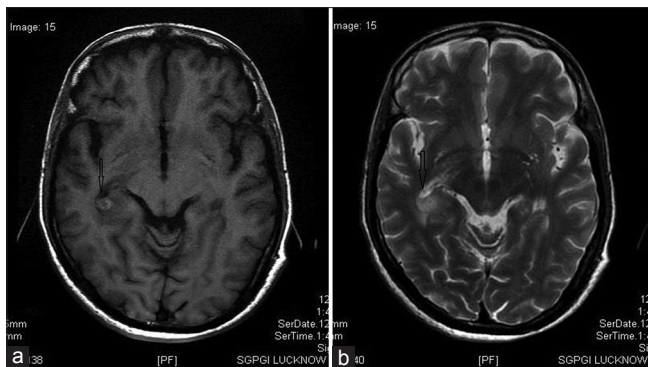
(a) Axial T1-weighted image showing rounded hyperintense lesion in the atrium of right lateral ventricle (arrow) with the surrounding white matter hypointensity suggestive of edema. (b) Axial T2-weighted image – same lesion is hyperintense (arrow) with the surrounding edema
